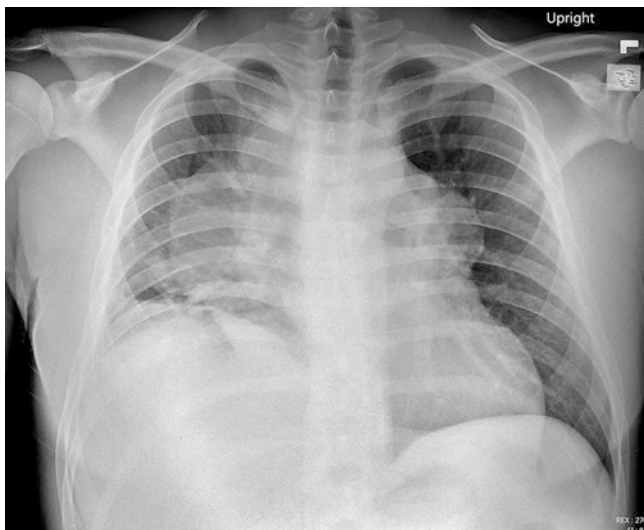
Radiographic evidence of mediastinal mass (lymphoma) with right-sided pleural effusion
